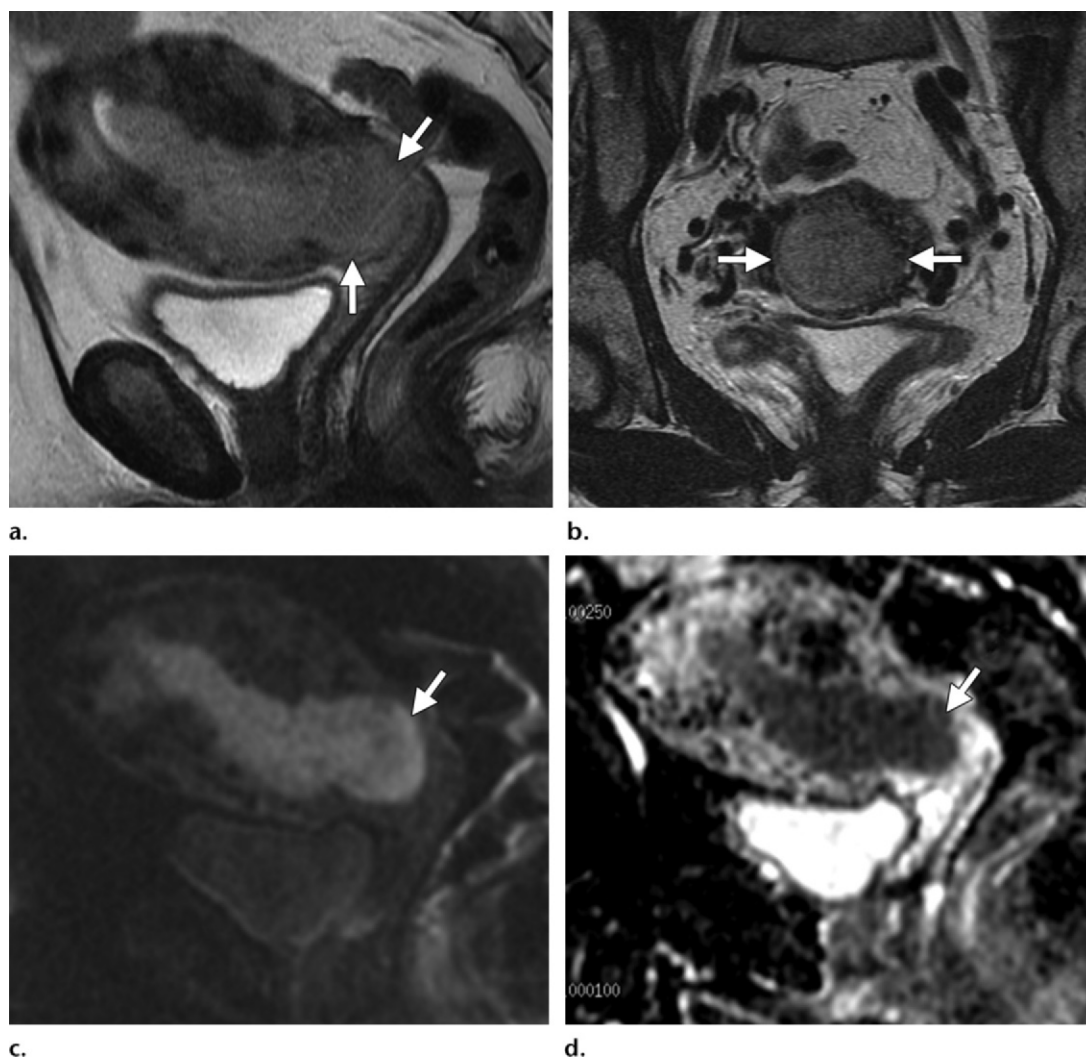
Stage II endometrial carcinoma (grade 3 endometrioid adenocarcinoma) in a 55-year-old woman. (a) Sagittal T2-weighted MR image shows an intermediate- to high-signal-intensity endometrial tumor (arrows) invading the normal, low-signal-intensity cervical stroma. (b) Axial oblique T2-weighted MR image, obtained perpendicular to the endocervical canal, shows the tumor (arrows) invading the cervical stroma but not the parametrium. (c, d) Sagittal diffusion-weighted image (c) and ADC map (d) show restricted diffusion within the endometrial tumor (arrow), with invasion of the cervical stroma and the outer one-half of the myometrium but not the serosa.
